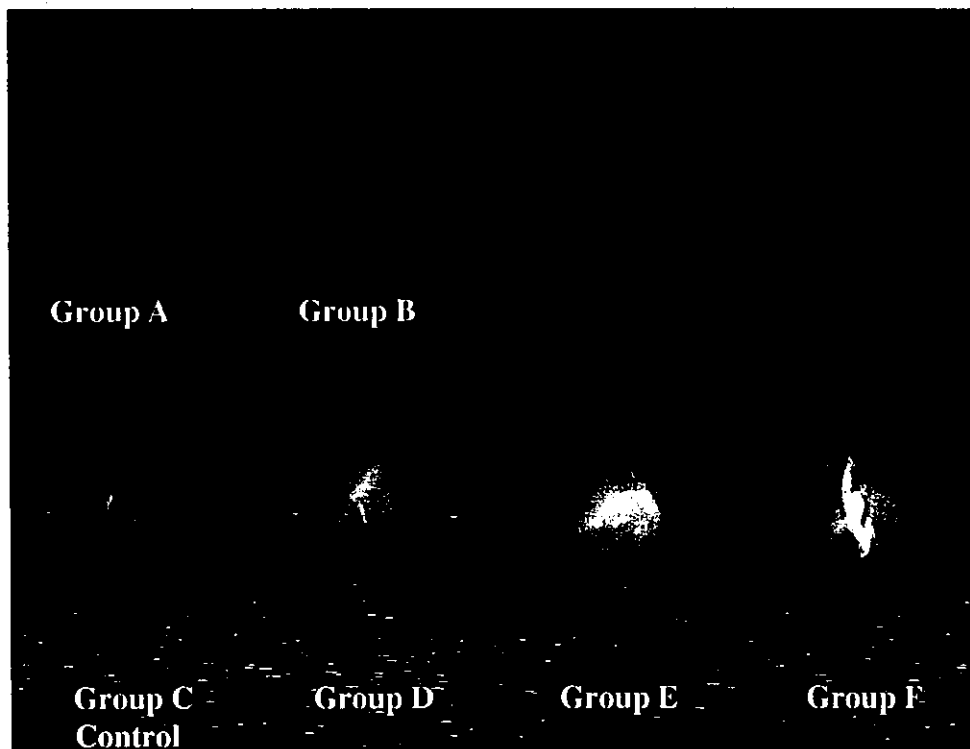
Soft X-ray images of calf muscles at 21 days after treatment.
